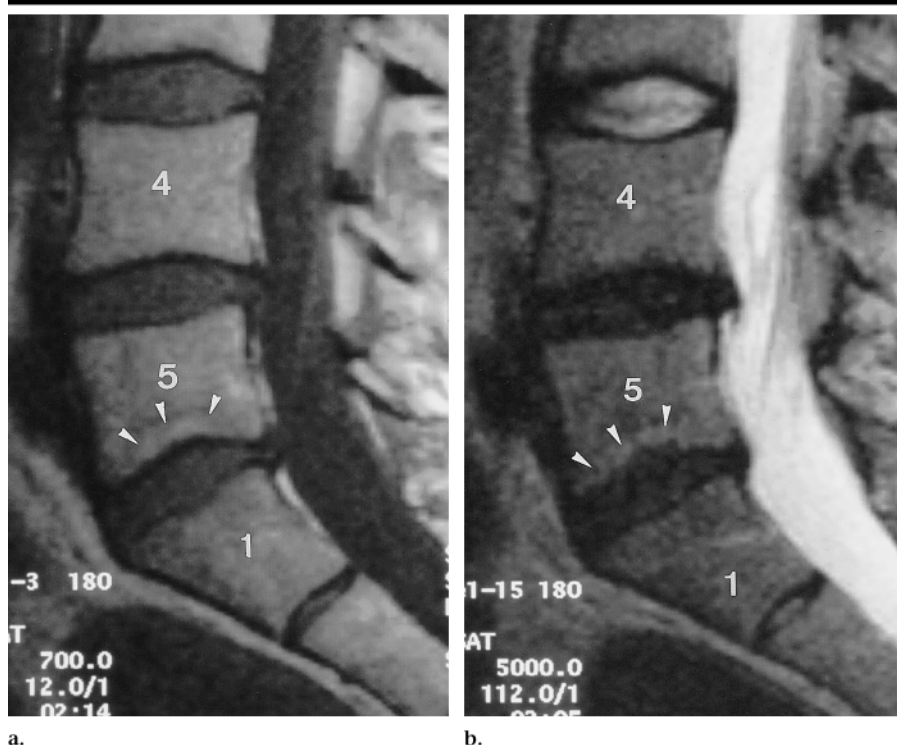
MR images of the lumbar spine in a 32-year-old woman with discogenic low back pain demonstrate the criteria used to identify mild endplate abnormalities. Sagittal (a) T1-weighted (700/12) and (b) T2-weighted (5,000/112) turbo spin-echo MR images demonstrate a small band of increased signal intensity (arrowheads) of bone marrow (cranial or caudal extent $\leq 25\%$ of the vertebral height as measured on a midsagittal image) adjacent to the upper endplate at the intervertebral disk level of L5 (5) to S1 (1) (type II endplate abnormality). There is grade 3 degeneration at the L5-to-S1 intervertebral disk level with disk bulging and grade 4 degeneration of the intervertebral disk at L4 (4) to L5 with disk bulging.
